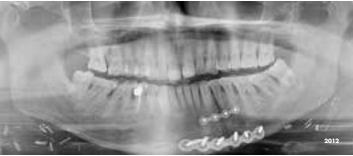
Sequential panoramic radiographs of Case 2 noting pathological changes.
